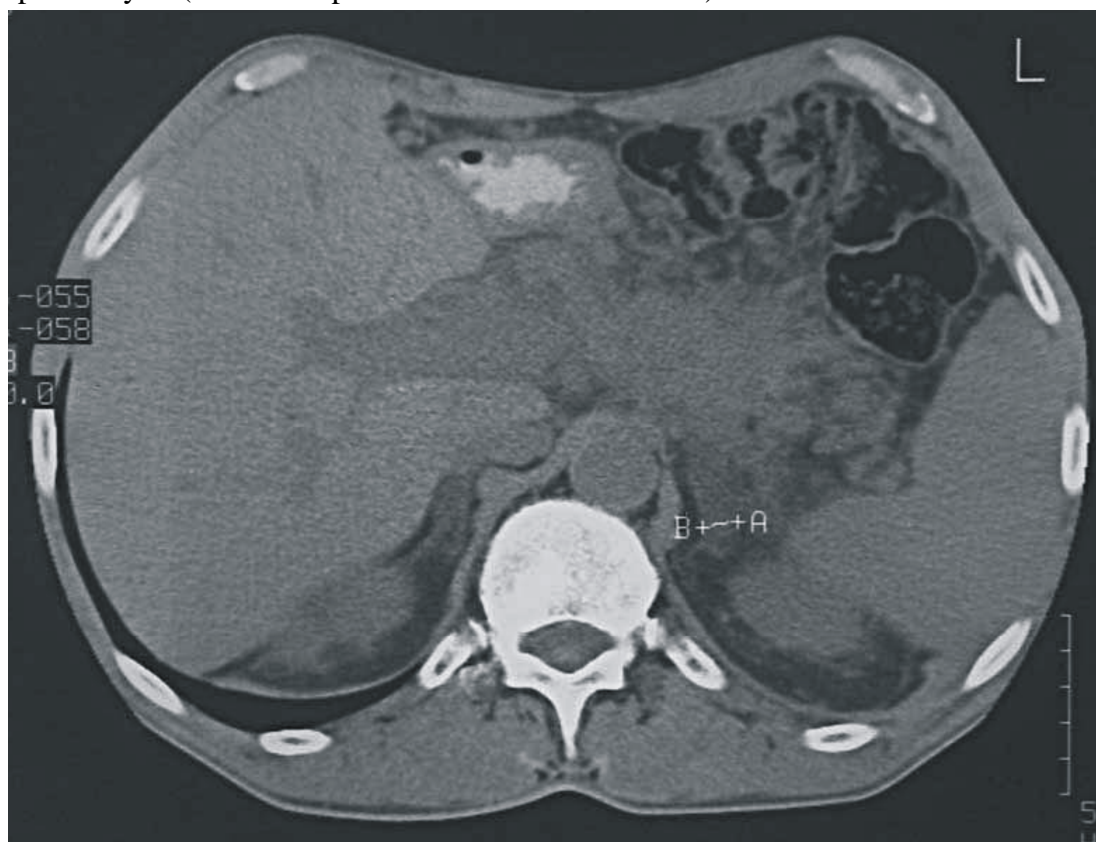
CT -- chronic pancreatitis with creation of paraaortal and paraoesophageal pseudocysts (in the retroperitoneum and mediastinum) with left--sided fluidothorax.
